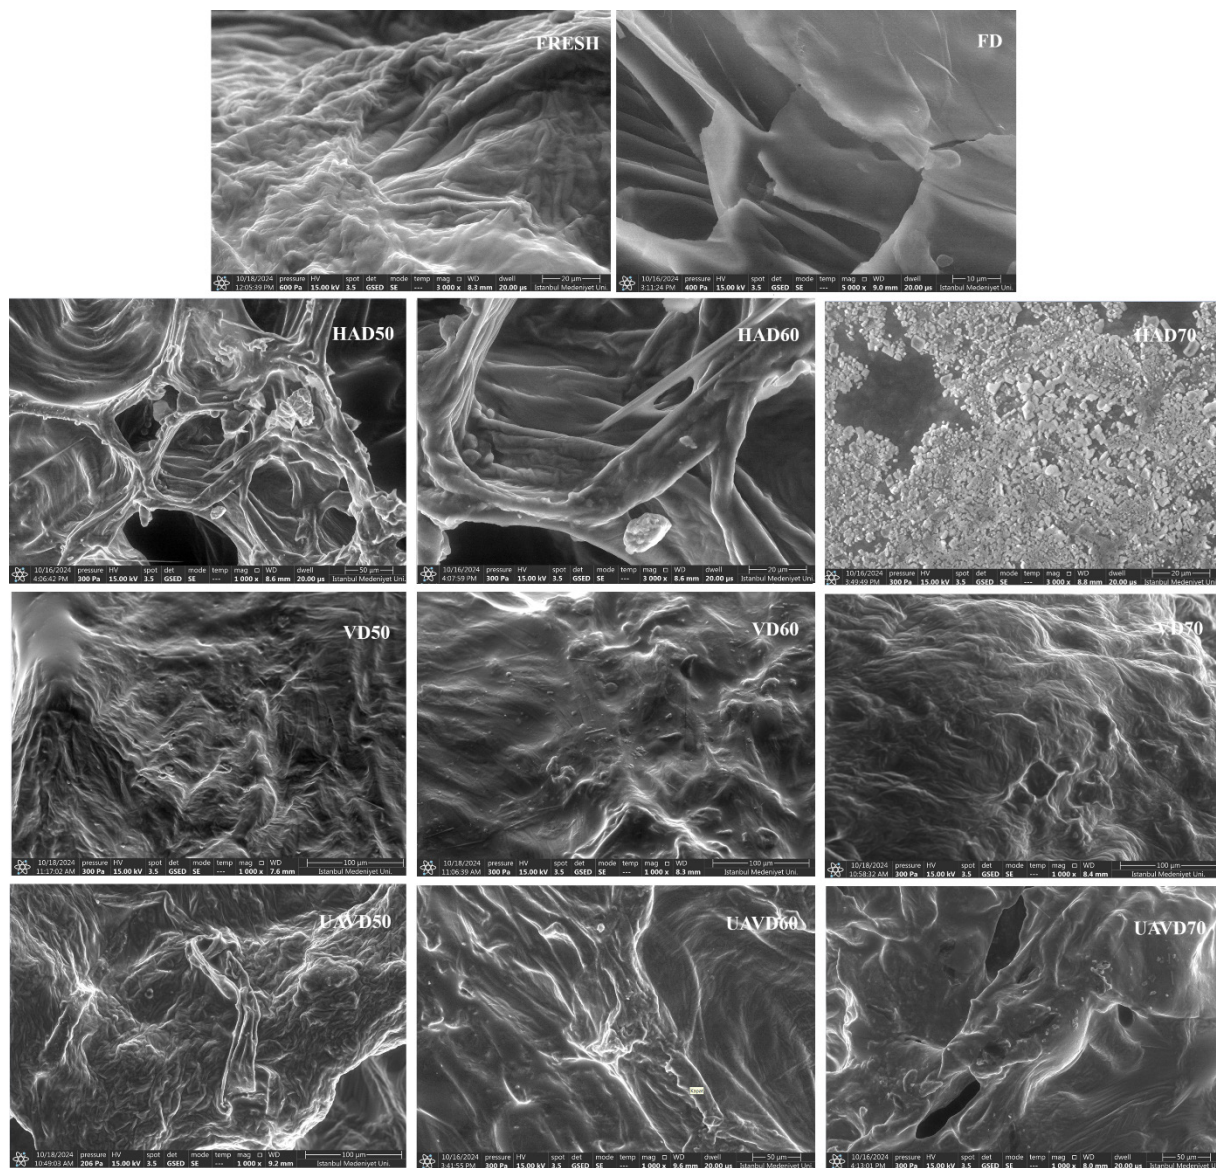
Microstructural images of dried and fresh kiwi fruits with different temperatures and drying methods. FD: freeze drying; HAD: hot air drying; VD: vacuum drying; TPC: total phenolic content; UAVD: ultrasound-assisted vacuum drying.
